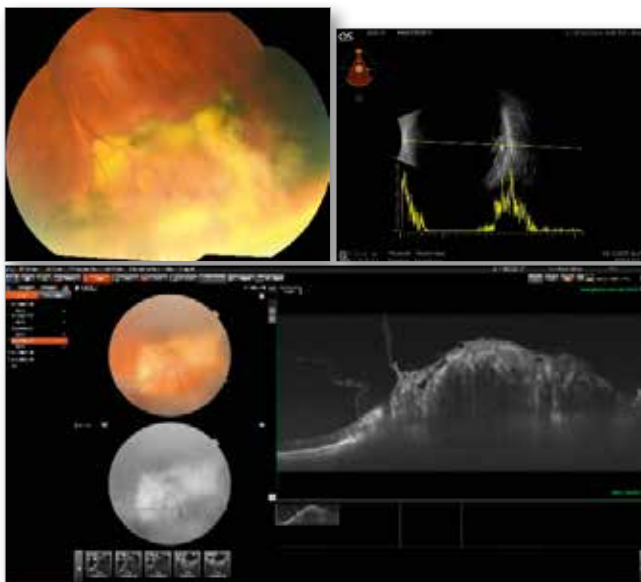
Vasoproliferative tumour colour picture, ultrasound, and OCT examination.
